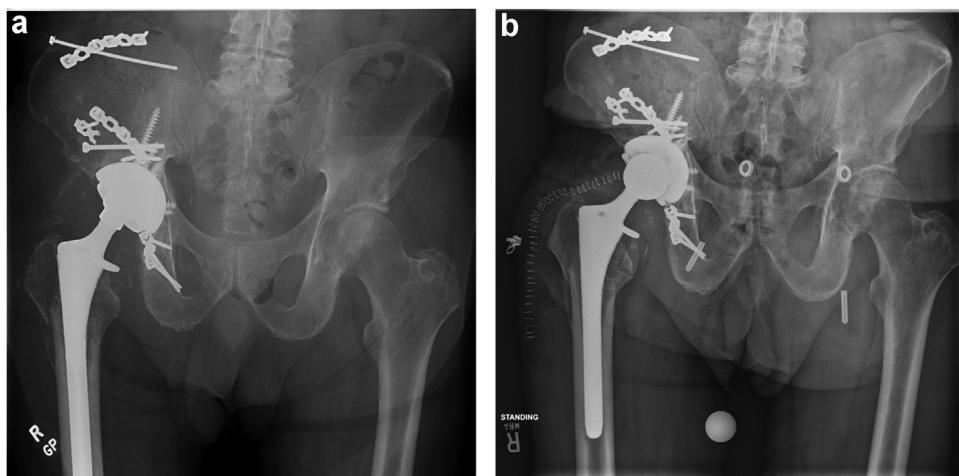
Case example demonstrating preoperative (a) radiographs of a patient with recurrent instability in the setting of a cemented dual mobility component. The patient was revised to a cemented constrained liner, and (b) the dual mobility component was removed using the technique contained within.
